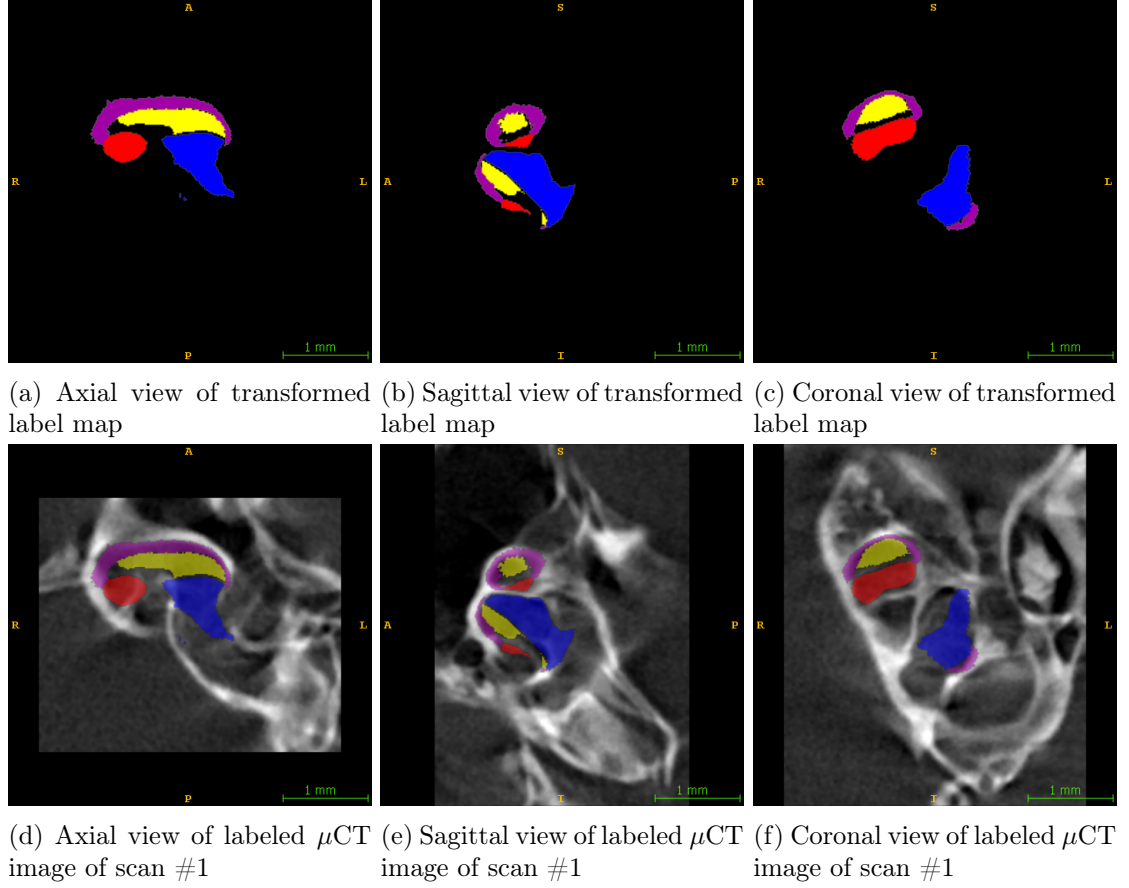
Three orthogonal 2D views of the transformed label map using the transformation output of B-Spline registration stage (the first row) and the labeled μ CT images of scan #1 (the second row). The left column are axial views, the center column are sagittal views and the right column are coronal views.
